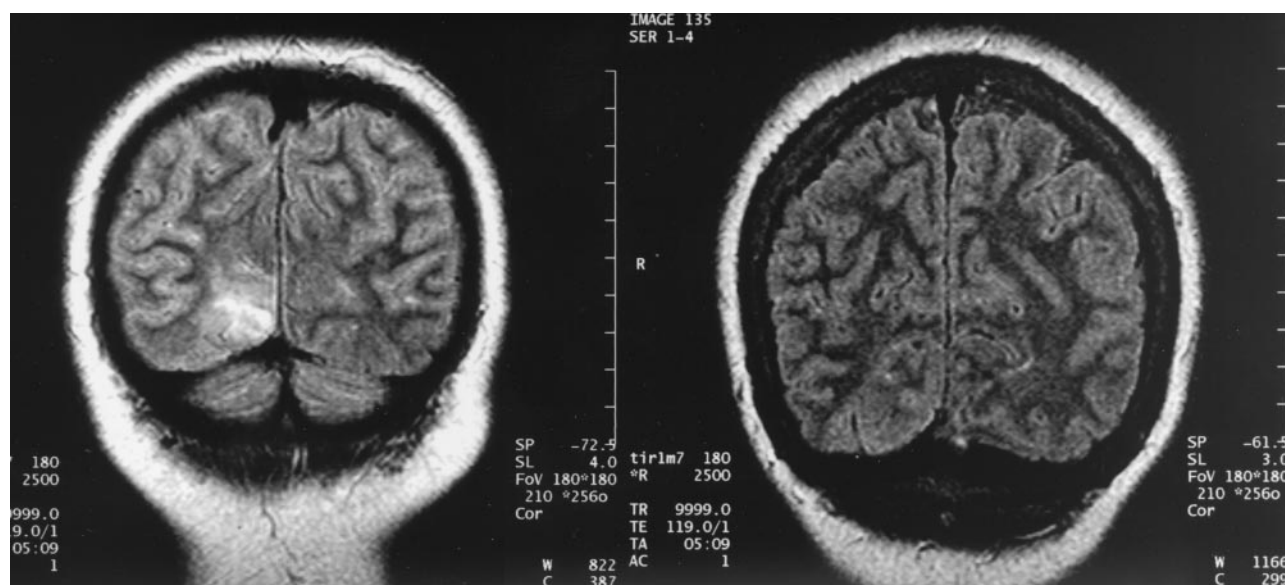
Coronal view FLAIR images from case 1 (left) and case 2 (right) (9999/119/1 [TR/TE/NEX]) show hyperintensity in the ganglioglioma within the right occipital lobe in case 1 and isointensity to normal gray matter in the benign cortical dysplasia in case 2.
